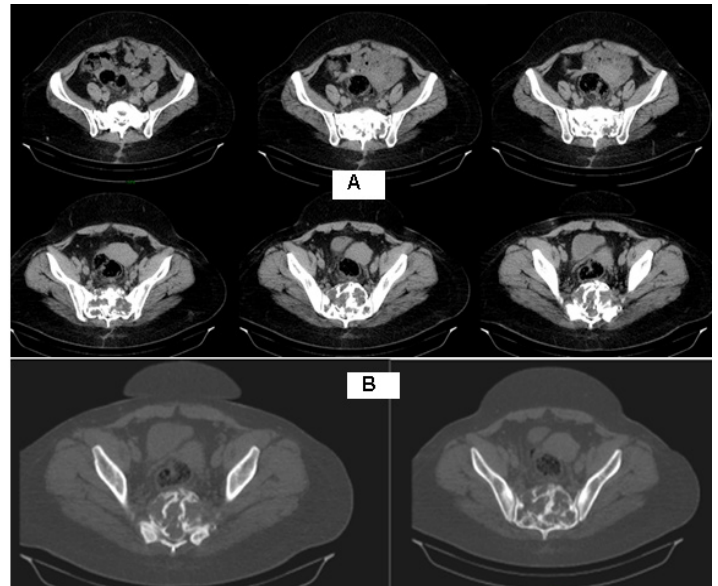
A/CT of the sacrum 6 months after definitive radiotherapy up to TD 64 Gy with DOD 2 Gy with a fibrous soft tissue component; B/ CT of a bone window
